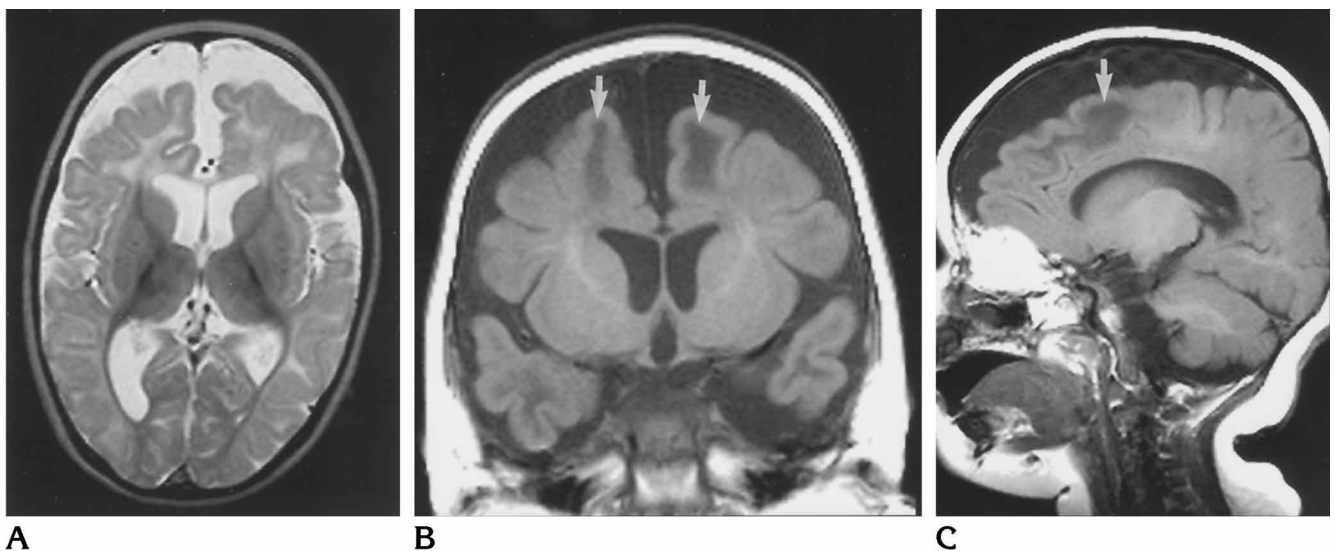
MR imaging in 10-month-old girl with MTHFR deficiency.
